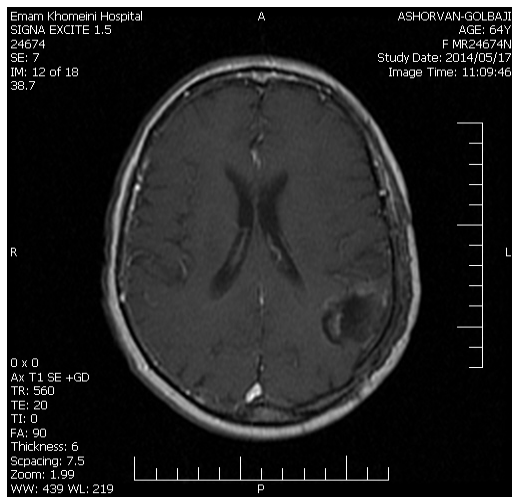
MR image demonstrating temporo-parietal mass with welldefined outline
